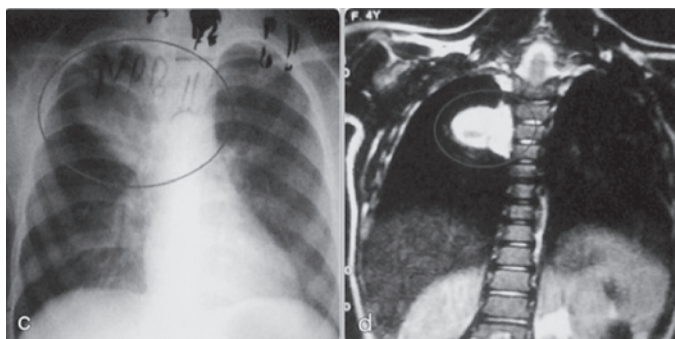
X-ray chest - Non homogenous opacity in right upper lobe
